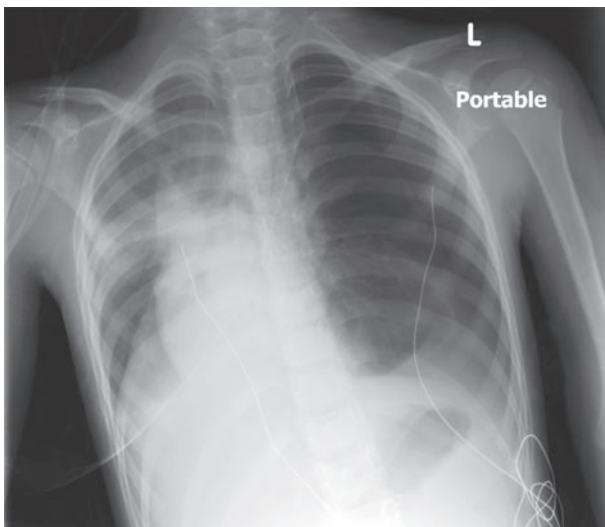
Chest radiograph showing left pneumothorax with mediastinal shift after operation.
